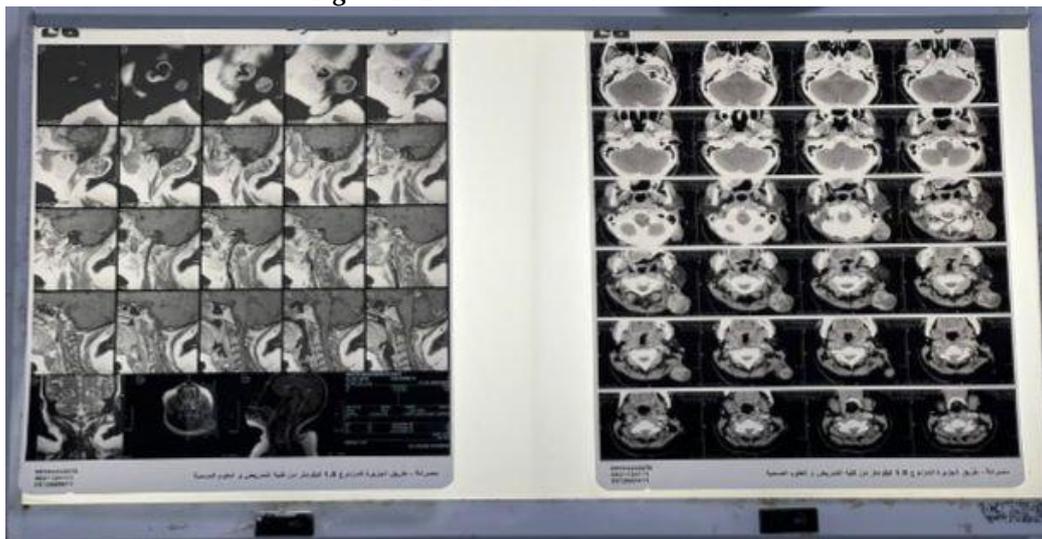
Neck MRI Imaging that revealed a retroauricular swelling
